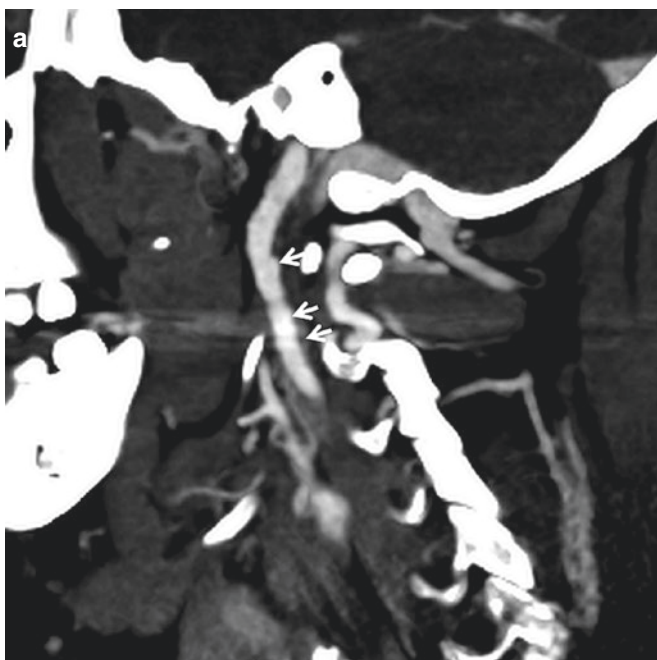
Vasospasm mimicking grade I injury in a patient with motor vehicle crash. Sagittal (a) and coronal (b) CTA neck demonstrates contour irregularity of right cervical ICA, which resolves in the repeat CTA
